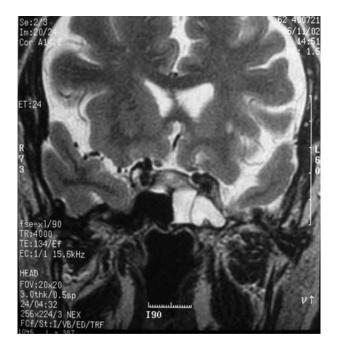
Spontaneous idiopathic CSF fluid leak in the lateral recess of the left sphenoid sinus. MRI Fast Spin Echo.
